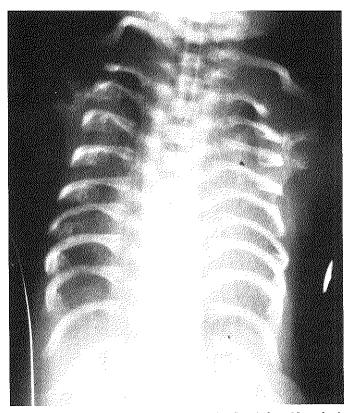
Radiograph of the thorax of the first infant. Note the handlebar clavicles, short horizontal ribs.
